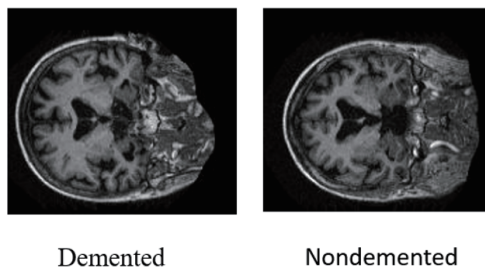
Magnetic resonance images from OASIS-1 data set.
